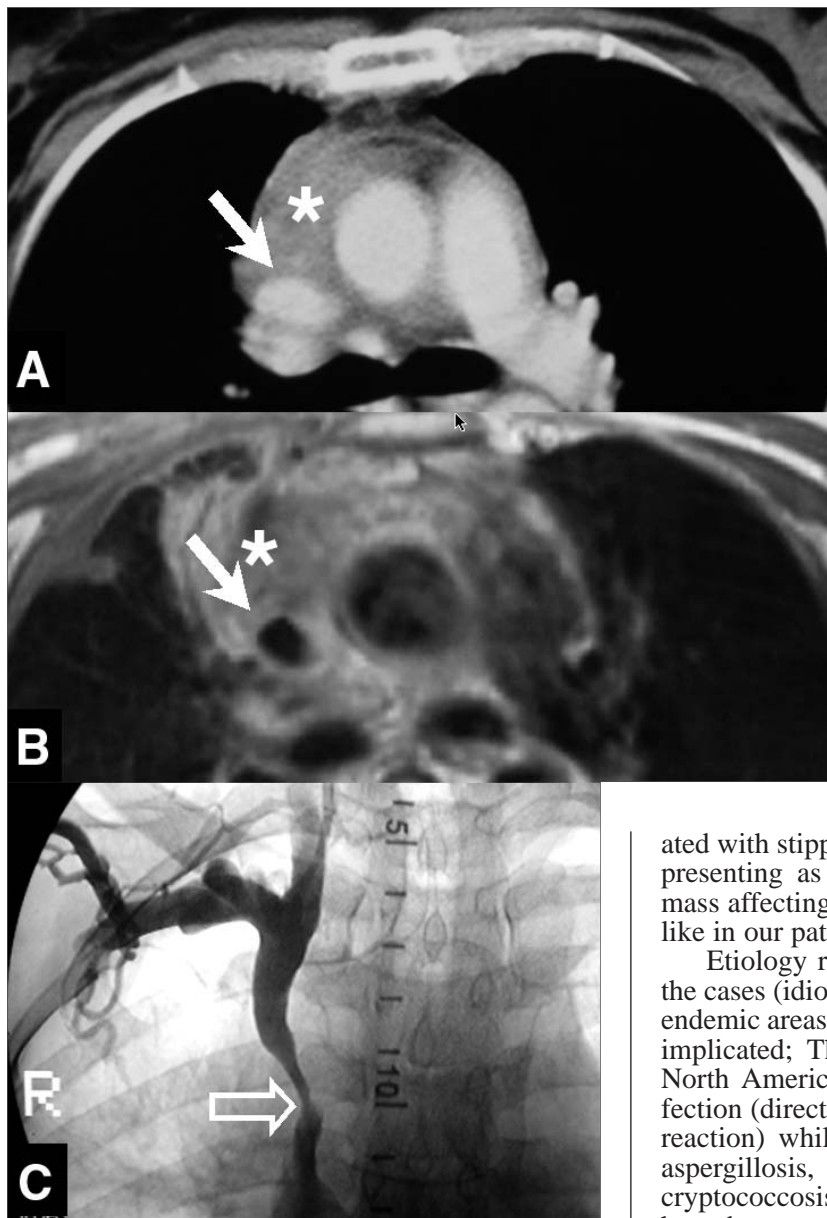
(A) Focused CT and magnetic resonance (B) sections show encasement of SVC (arrows) within a mediastinal soft tissue mass (asterisks). (C) SVC venography shows a marked stenosis (open arrow).
